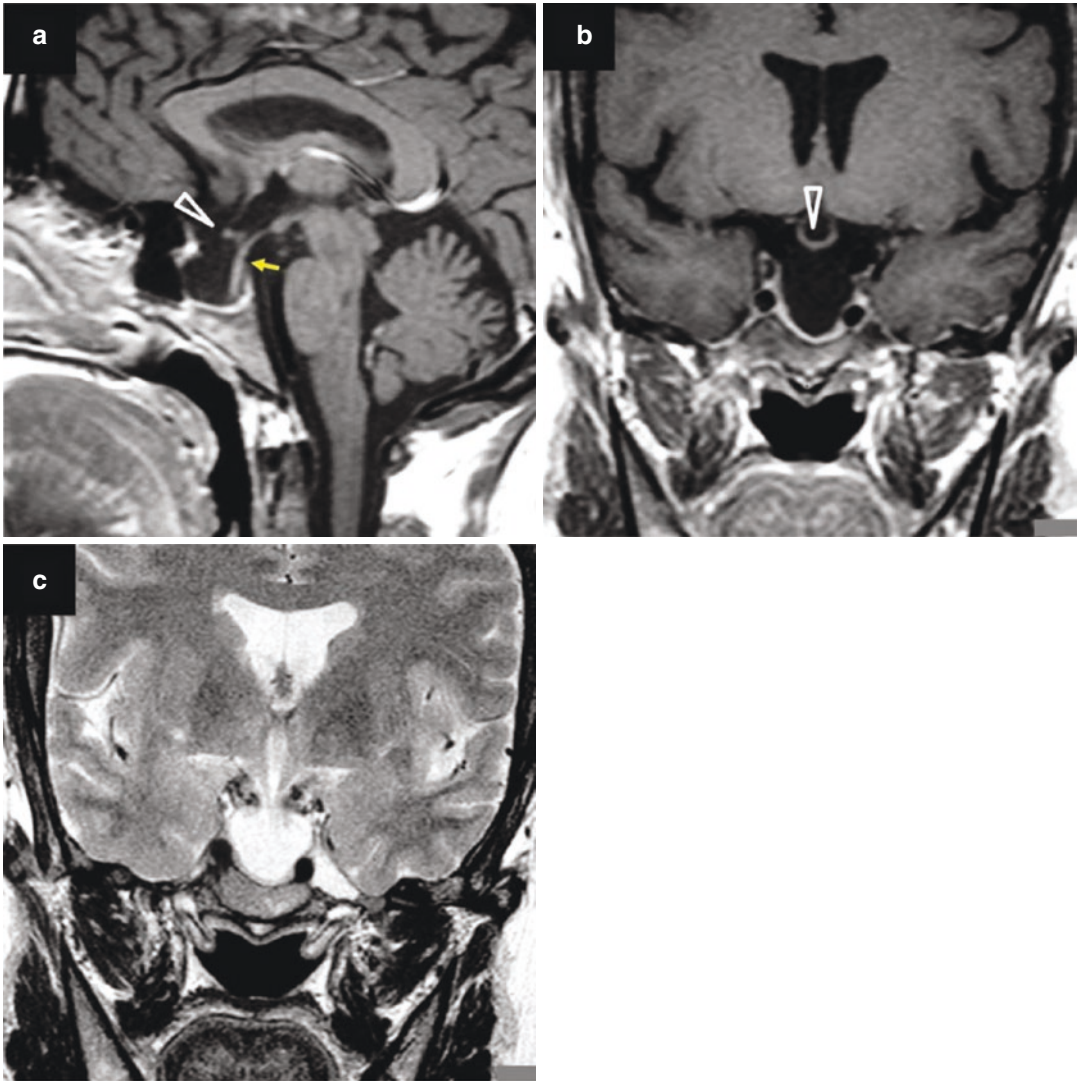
Giant cystic craniopharyngioma of the diencephalon. Sagittal T1- (a) and axial (b) and coronal (c) T2-weighted MR images. Note the enhancing solid part (arrow) on post-gadolinium sagittal T1-weighted MR image (d)
